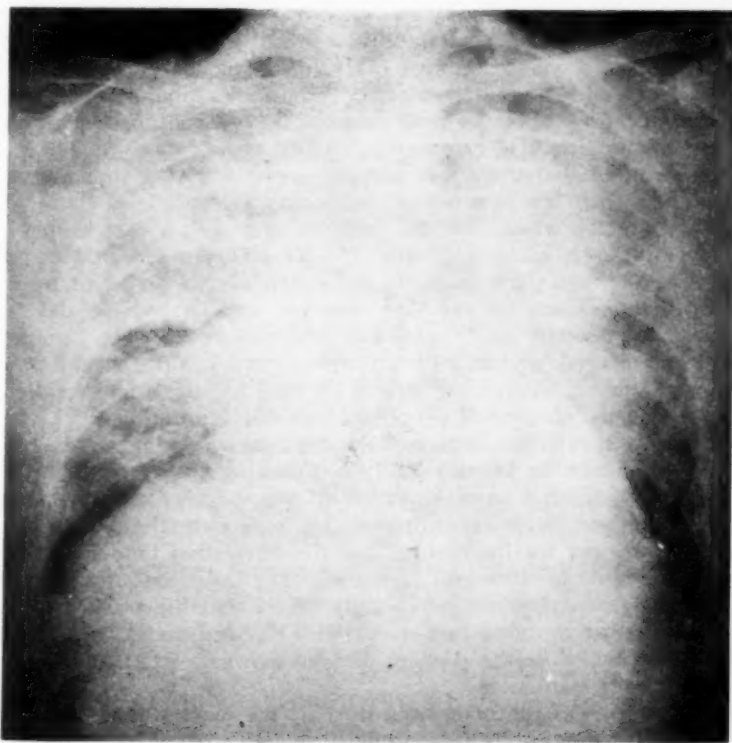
Chest roentgenogram of a 53 year old male with arteriosclerotic heart disease, taken shortly before death from congestive heart failure, shows the characteristic features of pulmonary edema. Despite its greater extent, note the striking resemblance of this infiltration to figures 9 and 12.
